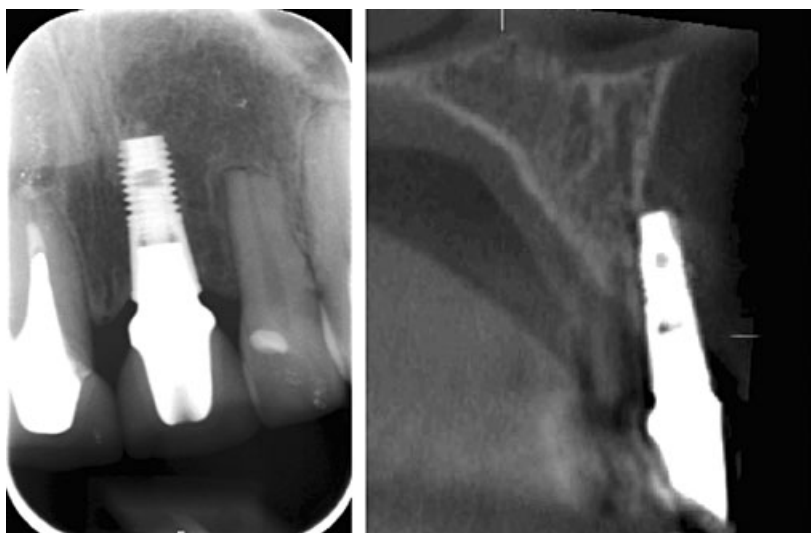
An intraoral radiograph (left) failed to reveal the cause of the problem in a patient with pain in the region of a newly placed implant. A DVT image demonstrated that most of the implant was not placed in the bone.
